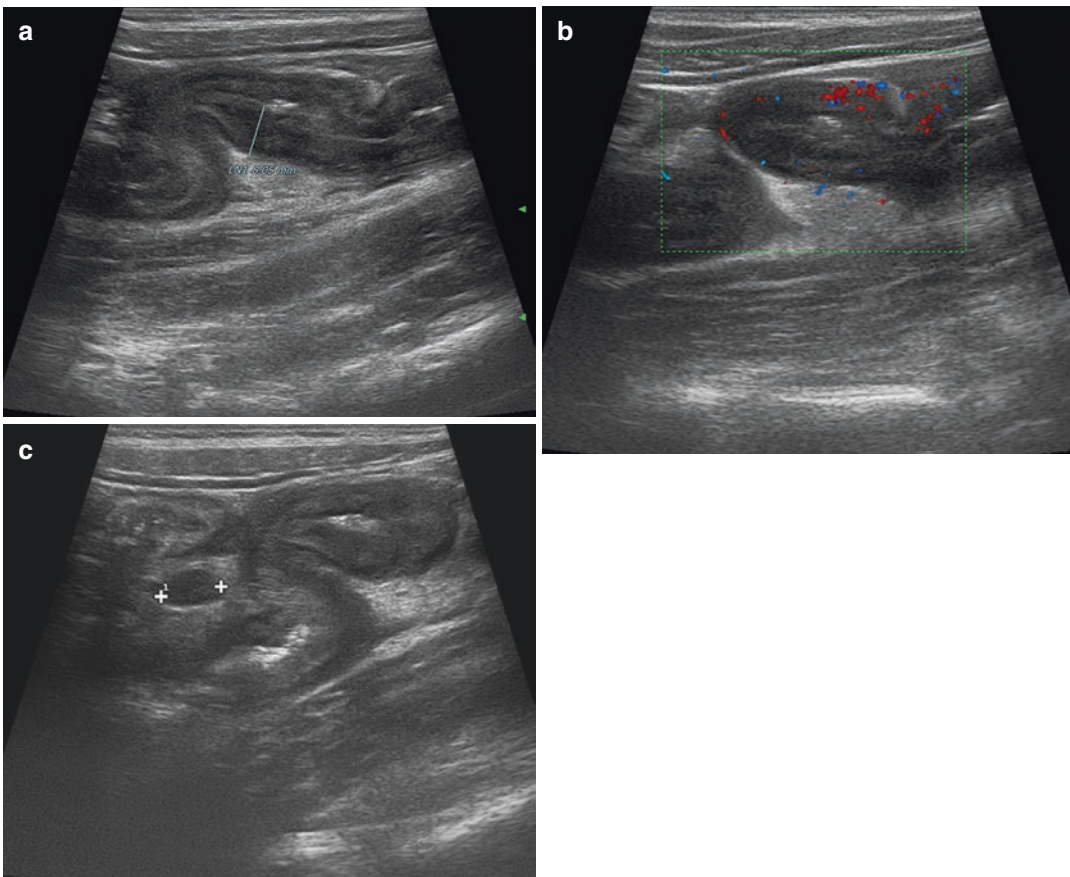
Small Intestine Contrast Ultrasonography (SICUS) performed on a CD patient. Wall thickening of the last ileal loop with luminal narrowing was detected (a)
